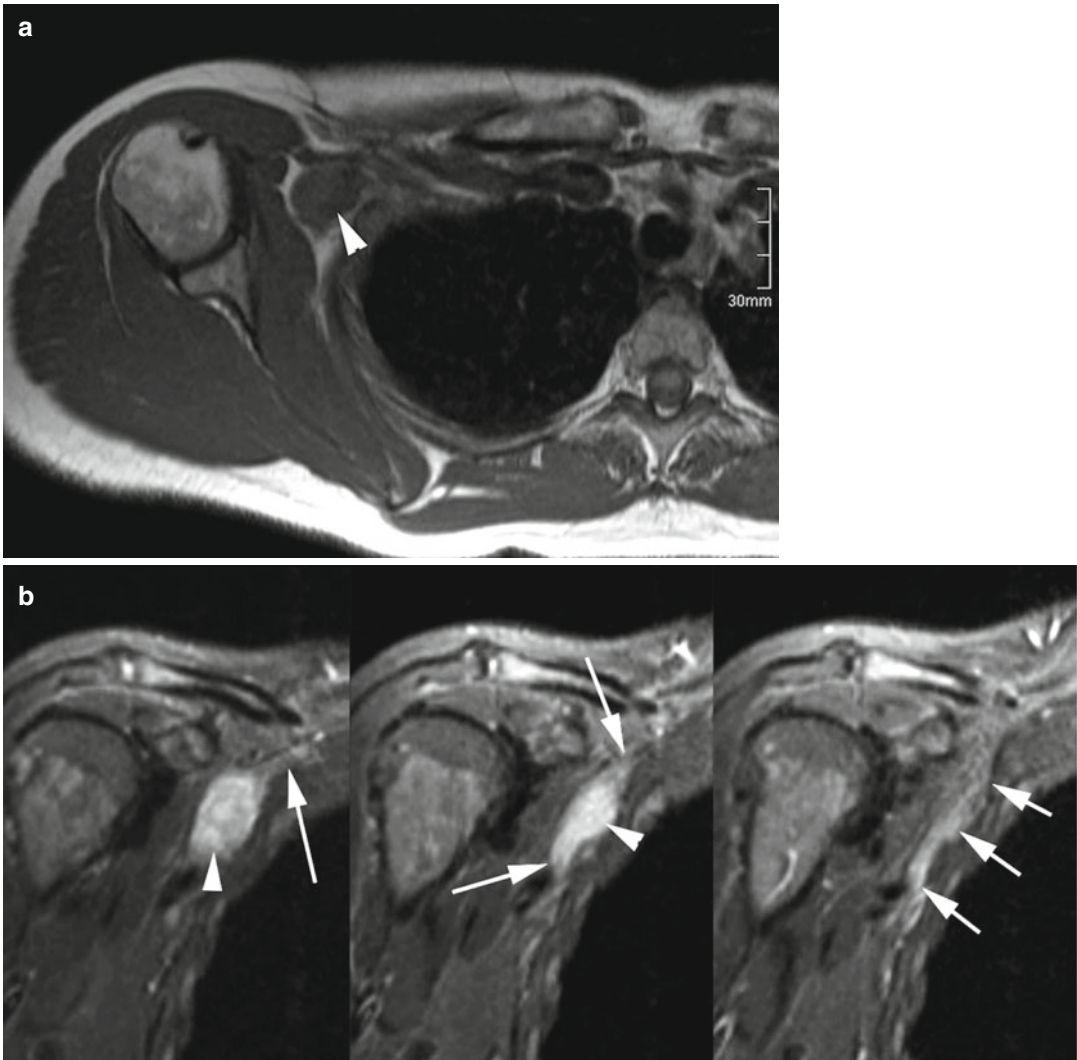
(a) Axial T1-weighted image at the level of the right shoulder joint. A slightly oval mass of indeterminate origin (lymph node, primary soft tissue tumor) is noted in the axillary space (*arrowhead*). Note the progressive, cone like enlargement of the nerve at the proximal and distal
